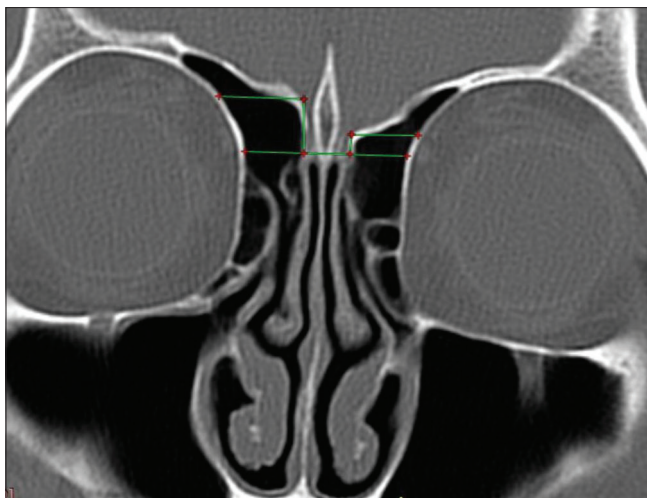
Coronal CT scan showing asymmetry in the depth of OF on either sides. Difference of >2 mm is seen in the OF depth between two sides. Both sides have different Keros type OF (type III on right and type I on left side)
